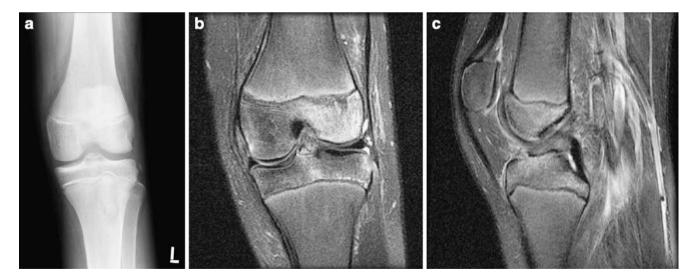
Knee pain after a twisting injury while playing basketball. a AP radiograph of the knee in a 15-year-old boy who developed knee pain after a twisting injury while playing basketball demonstrates a small fracture fragment adjacent to the proximal tibia consistent with a Segond fracture. A small fracture fragment is also visualized adjacent to the tibial spine. b, c Coronal and sagittal T2-W fat-suppressed MR image of the knee in the same patient demonstrates findings of the Segond and tibial spine fractures (marrow edema and cortical discontinuity). While the ACL is intact, it is no longer functional due to the tibial spine avulsion fracture. Edema of the lateral femoral condyle is consistent with the kissing contusion pattern commonly seen with ACL injury Fig. 9 Sinding-Larsen-Johansson lesion. A close-up lateral view of the knee in a 12-year-old boy with chronic knee pain demonstrates fragmentation of the inferior pole of the patella. The patient was tender to palpation in this area
